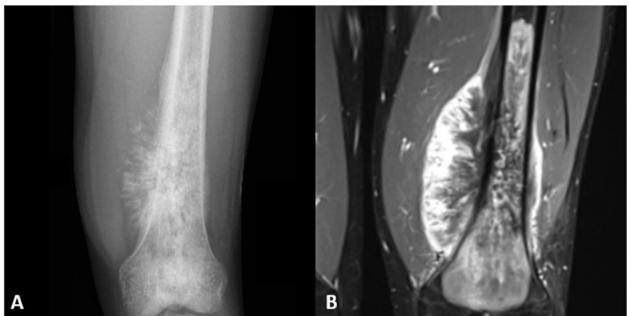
(A) X-ray an osteosarcoma of the distal femur shows the classic "sunburst" appearance and "Codman Triangle" or periosteal lifting. (B) Magnetic resonance imaging shows notable extension beyond the femoral cortex and avid contrast enhancement.
